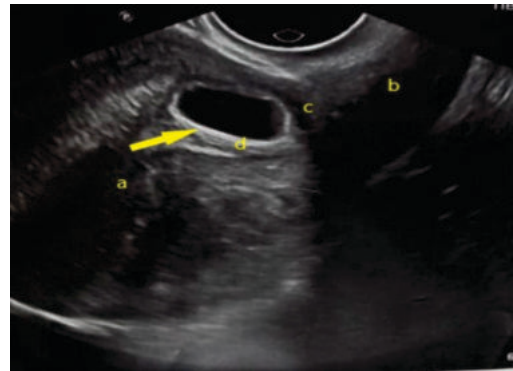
Transvaginal ultrasound showing caesarean scar ectopic pregnancy.
